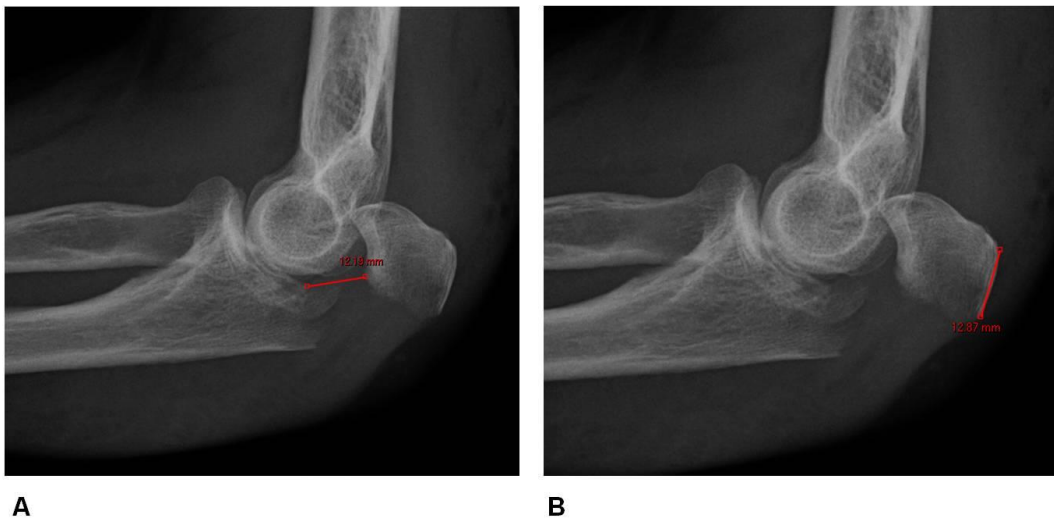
A: Measurement of articular displacement for fractures of the olecranon on the lateral radiograph. B: Measurement of the distance from the tip of the olecranon to the level of the fracture.
